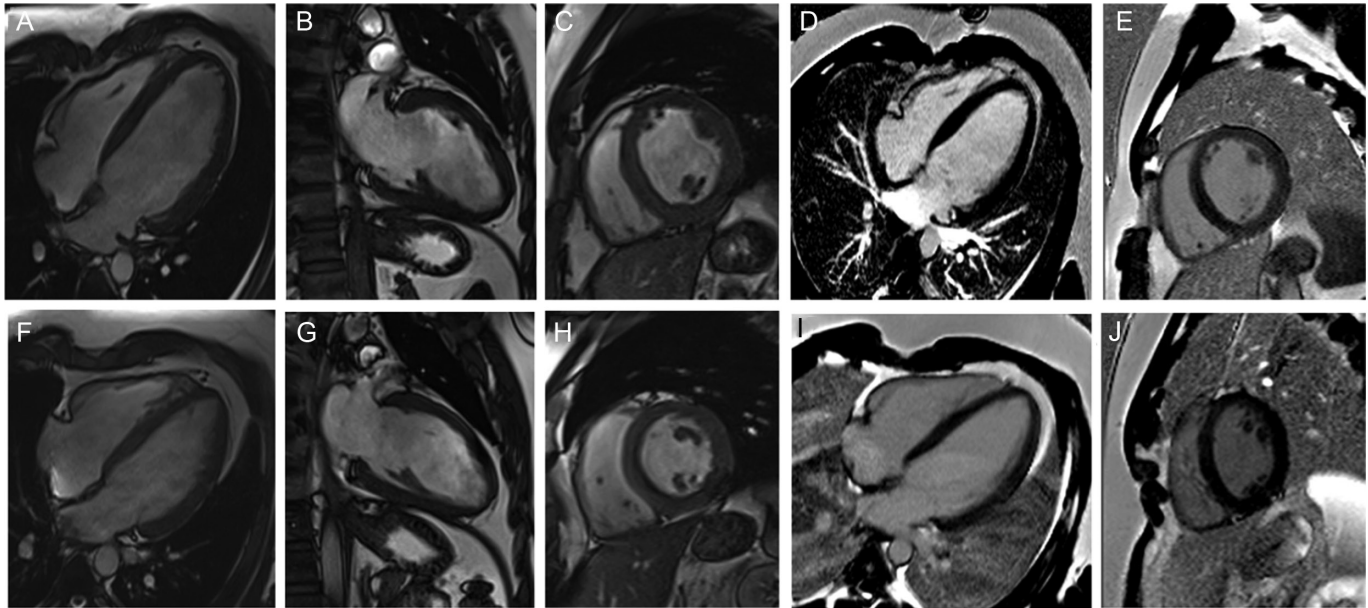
Cardiac MRI images of the cases. (A-E) cardiac MRI images of case 1 showing global hypokinesis with no LGE. (F-J) cardiac MRI images of case 2 are within normal limits with no LGE (Video 5-6-7-8-9). MRI, magnetic resonance imaging; LGE, late gadolinium enhancement.
